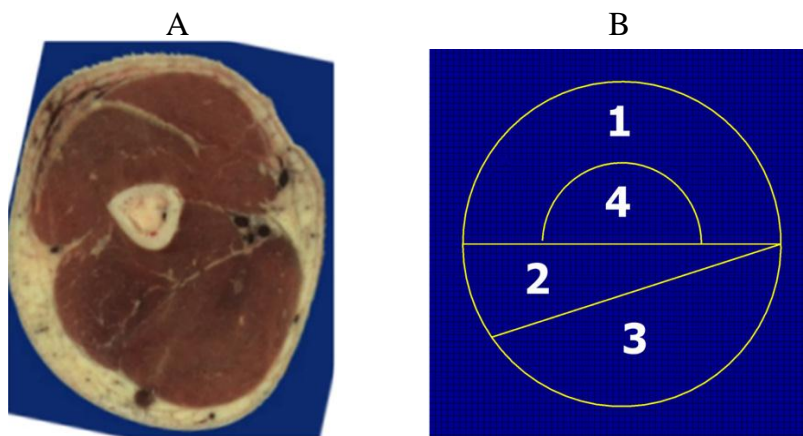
A. Upside down MRI of upper arm muscles. B. Modeling upper arm muscles in 4 areas: 1 and 4: Triceps; 2: Brachialis; 3: Biceps (from [56], Fig 2).
